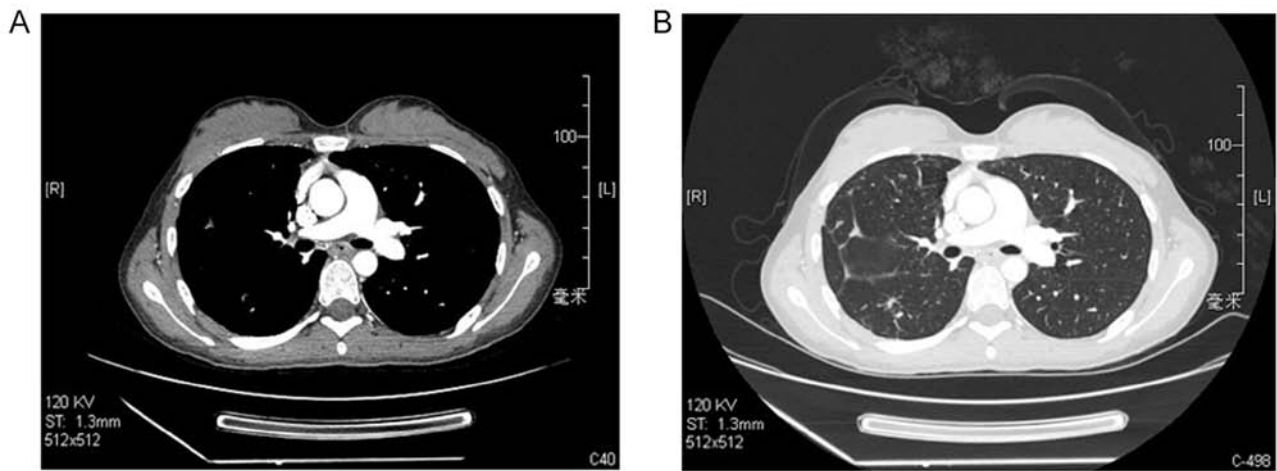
Contrast-enhanced chest CT images of pulmonary embolism by choriocarcinoma after 12 cycles chemotherapy. (A) Contrast-enhanced chest CT (mediastinal window setting) scan image showing no occlusion within the right pulmonary artery. (B) Chest CT (lung window setting) scan image showing cordlike, nodular fuzzy shadows in the right lung.
